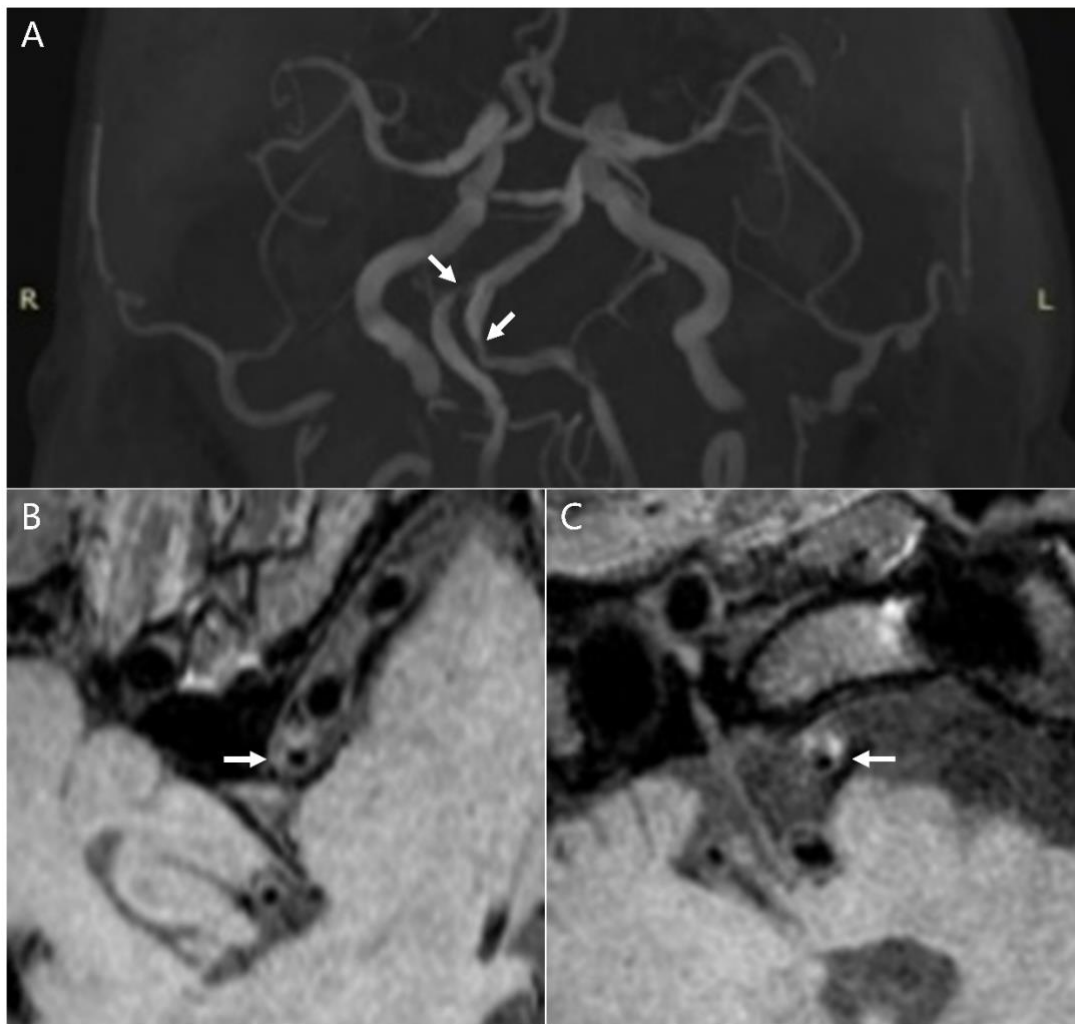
A 62-year-old male patient with acute posterior-circulation infarction. A, an asymptomatic atherosclerotic stenosis of the right VA and a symptomatic atherosclerotic stenosis of the left VA on the MRA image (white arrows). B and C, the eccentric, focal plaques in the right and left VAs on the T1w images, respectively (white arrows). MRA, magnetic resonance angiography; T1w, T1-weighted; VA, vertebral artery.
